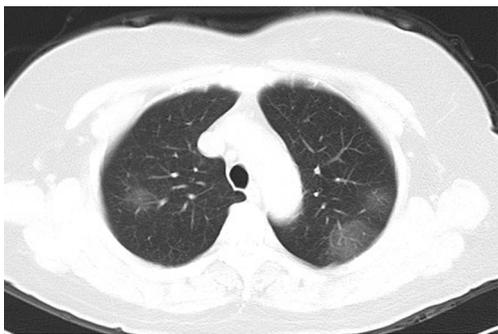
Ground glass opacity (GGO) in a 68-year-old female with confirmed COVID-19. Axial CT images shows multiple round morphology of GGOs in the bilateral upper lobes. Lesions are located in peripheral lung fields.
